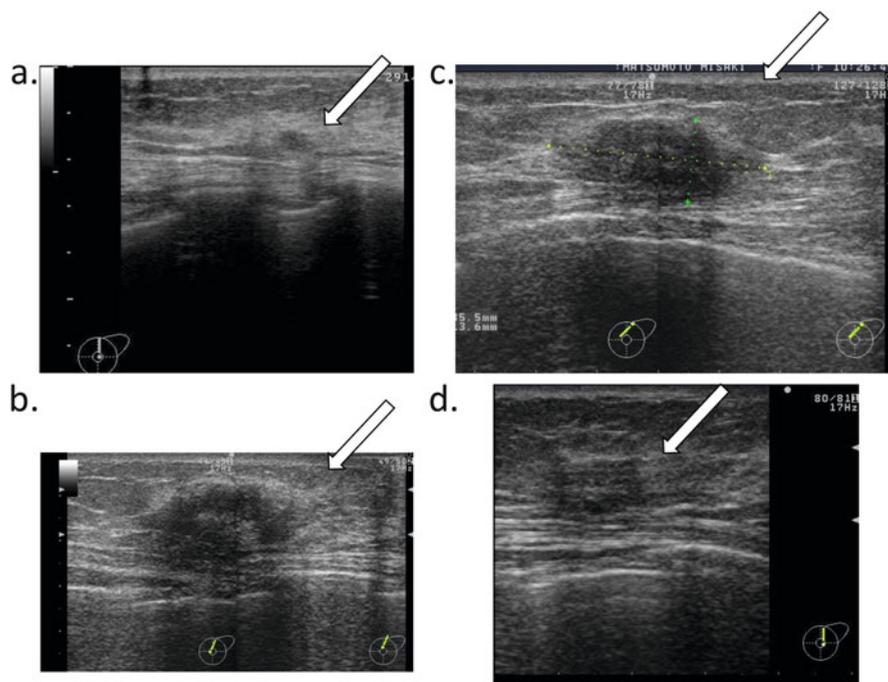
Serial changes of ultrasonography after cryoablation. (a) Preoperative ultrasonography: the lesion was indicated with *white arrow*. (b) Six months after cryoablation: granulation was indicated with *white arrow*. (c) Fifteen months after cryoablation: Granulation is smaller than at 6 months. (d) Forty-seven months after cryoablation: granulation was smaller than at 15 months but still there
